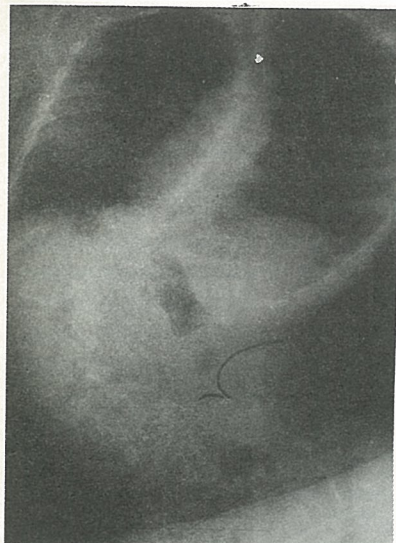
13 years old female preoperative X-ray.
